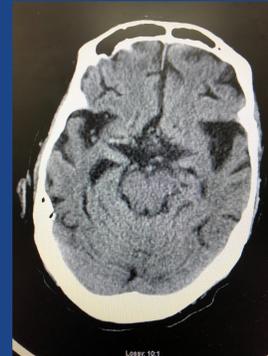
CT head without contrast, which showed a focal hyperdensity of the proximal right middle cerebral artery
